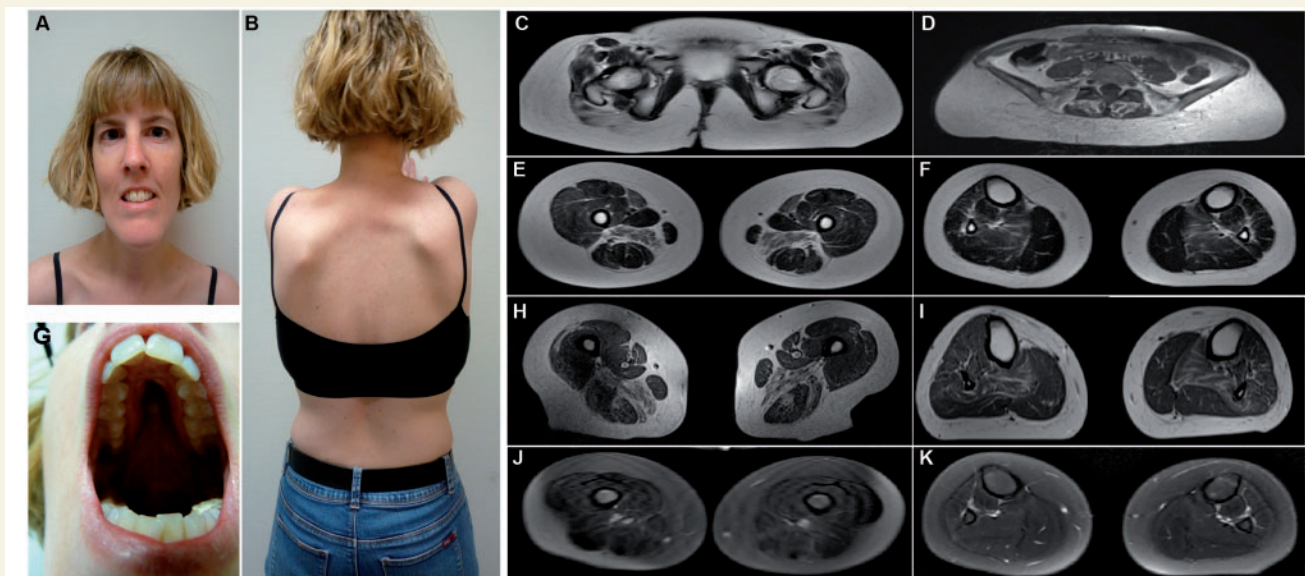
Clinical features in SCN4A congenital myopathy patients. Clinical images of the proband from Family 2 show mild facial weakness, elongated face (A), high arched palate (G) and bilateral scapular winging (B). T₁-weighted muscle MRI images in the affected case from Family 1 (at age 6 years) (C, E and F) and in the proband from Family 2 (at age 35 years) (D, H and I) showed severe involvement of the gluteal muscles (C and D), bilateral, symmetric involvement of sartorius and adductor magnus in the upper leg (E and H) and involvement of soleus in the lower leg (F and I). T₂-weighted muscle MRI images in the affected case from Family 1 demonstrated no oedema (J and K).
